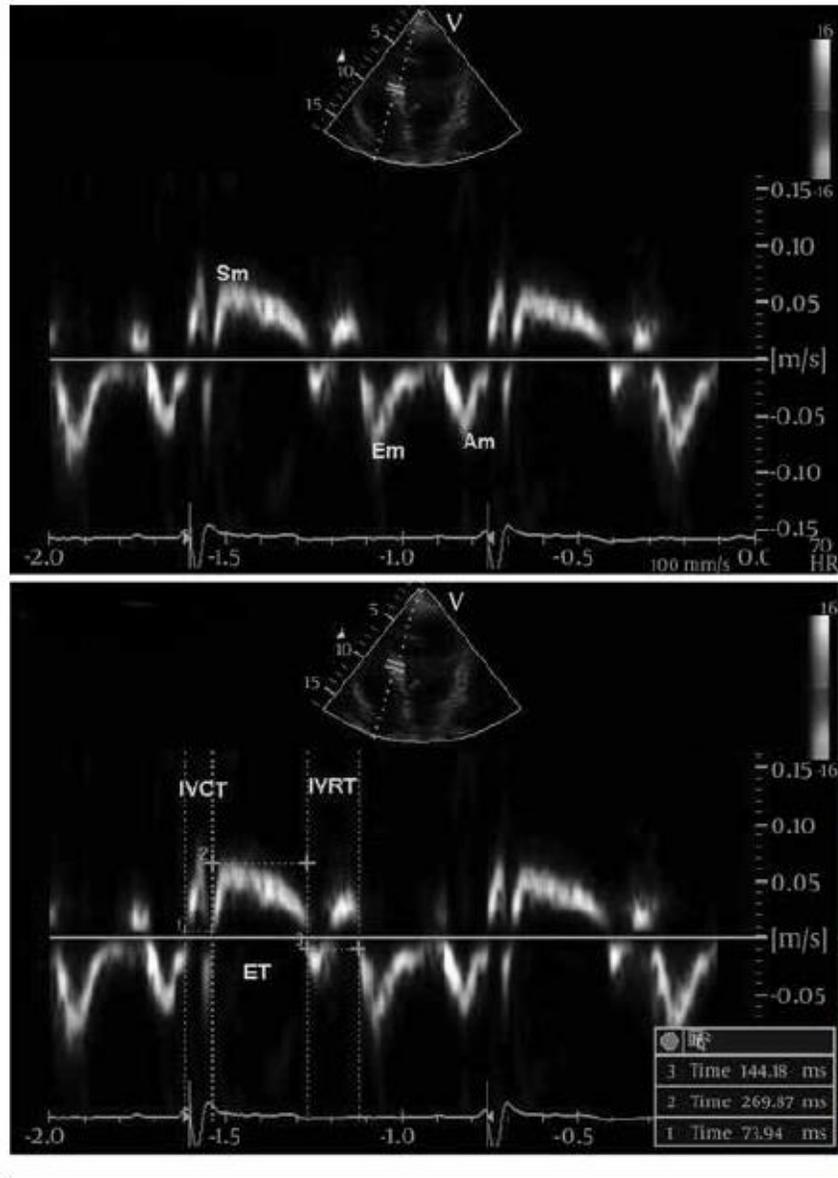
Pulsed-Wave Tissue Doppler Measurements at the Septal Mitral Annulus of a Patient With AR
